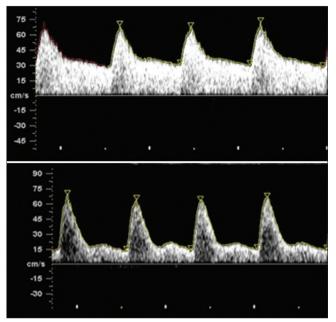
Abnormal uterine artery Doppler view with notch [9]
